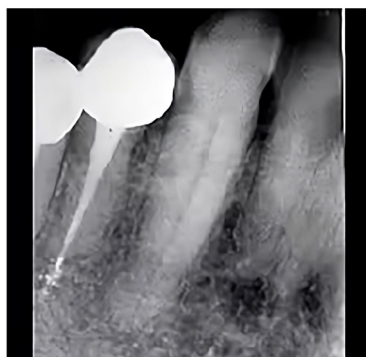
Periapical preoperative x-ray.
